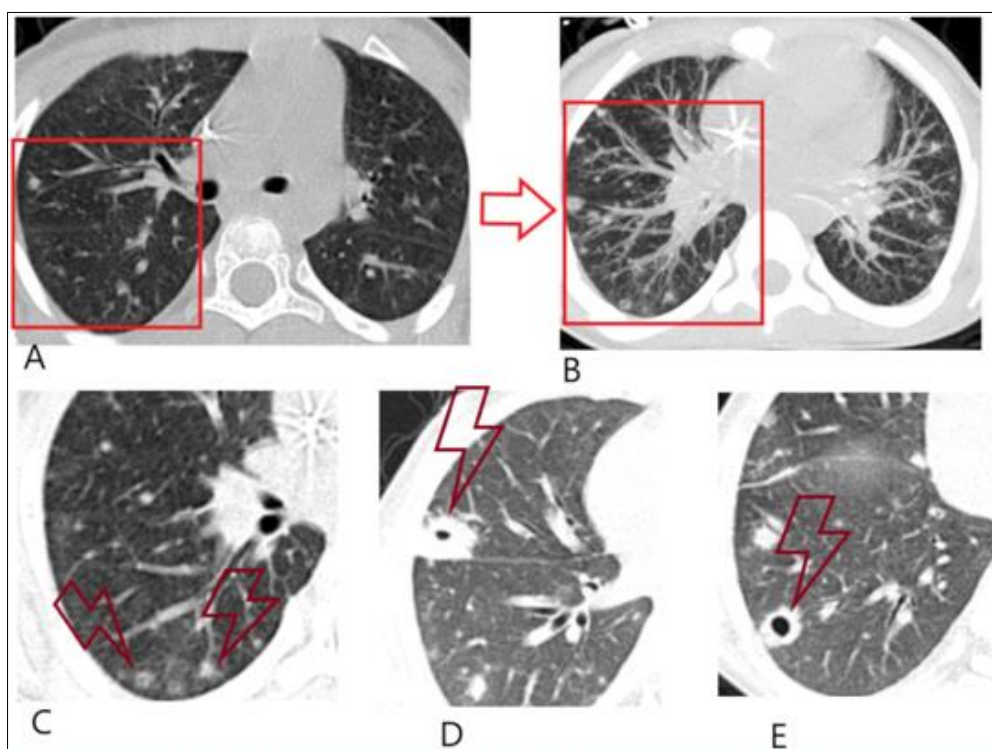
pulmonary involvement on CT scan:
